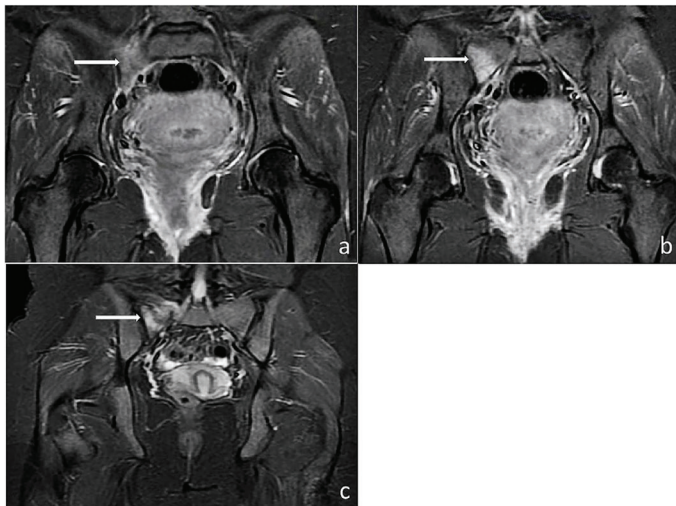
(a,b) Coronal STIR images demonstrating the fracture line in the right sacrum (arrow). (c) Coronal T2 fr FSE FSat MRI image of the same fracture (arrow)
